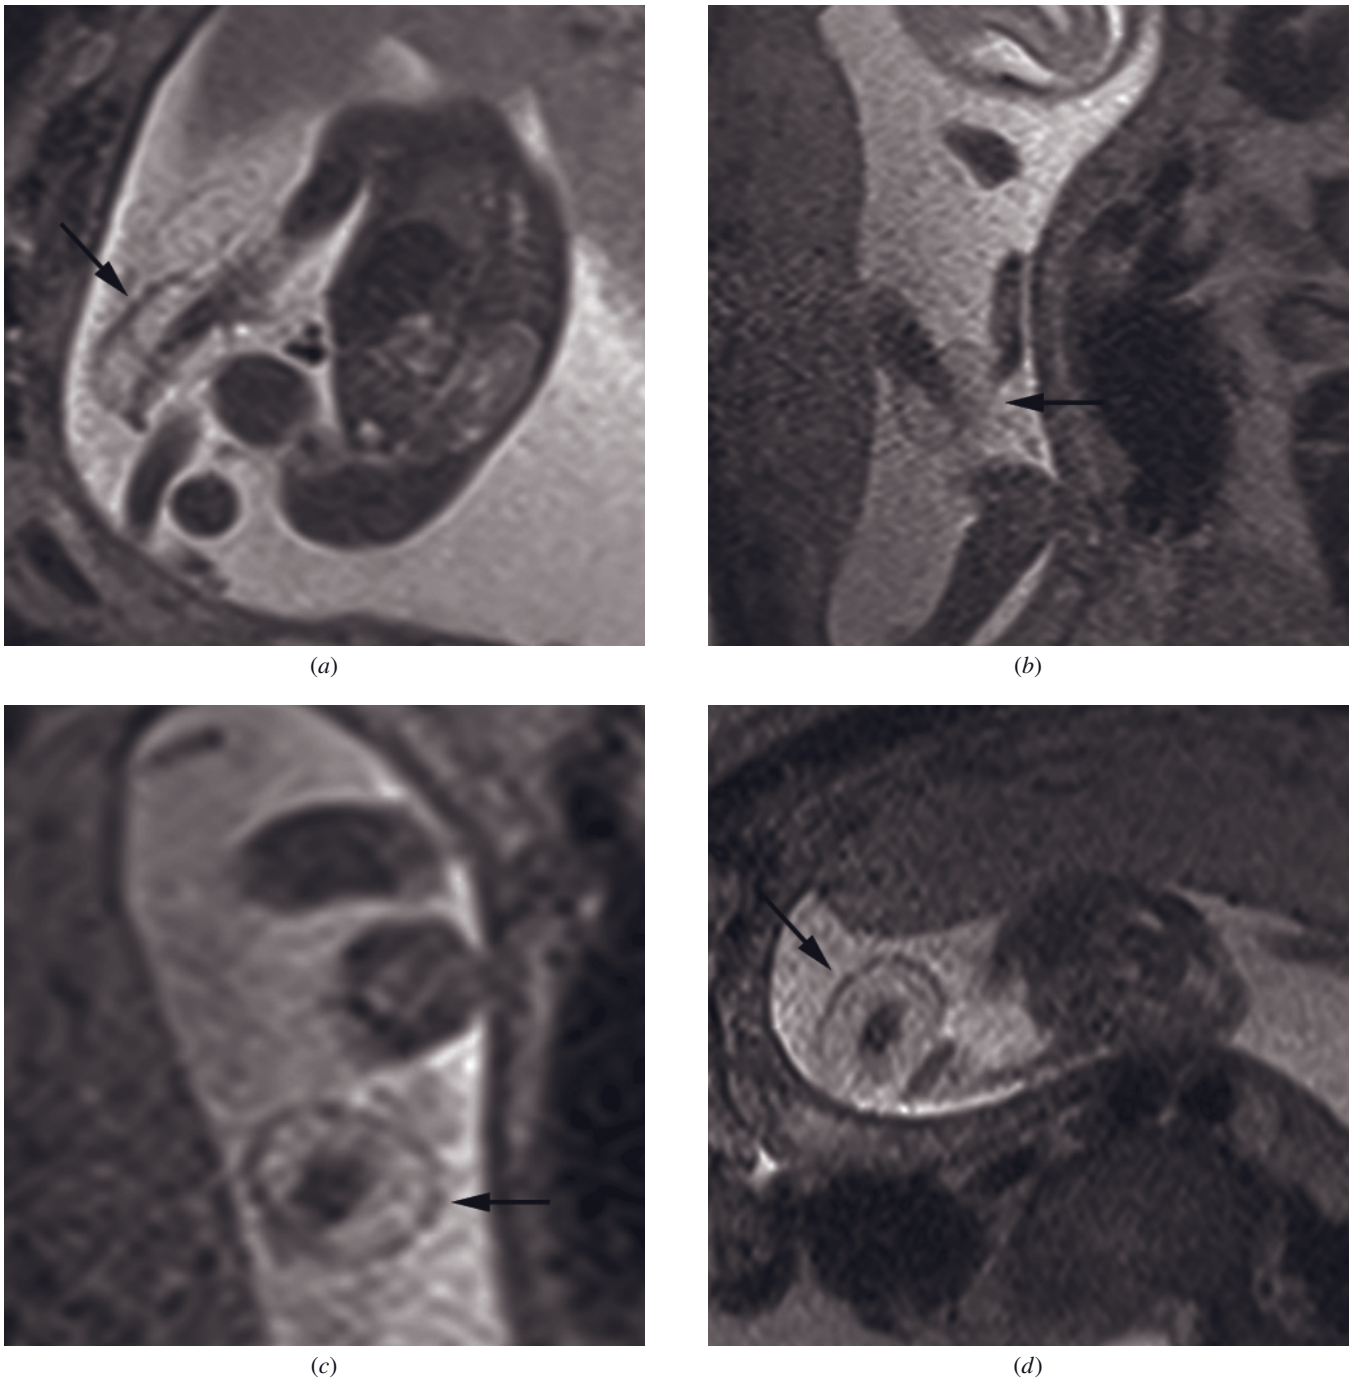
Amniotic band of upper extremity with associated hand edema. T2-weighted SS-ETSE sequence performed in four planes (*a-d*) to evaluate upper extremity reveals a cystic mass surrounding the right forearm and extending to the distal interphalangeal joints (arrows). There is edema of the hand; however, the remainder of the arm is of normal caliber, similar to the contralateral normal-appearing arm. Contrast enhancement (not shown) demonstrated no flow within this cystic mass.
